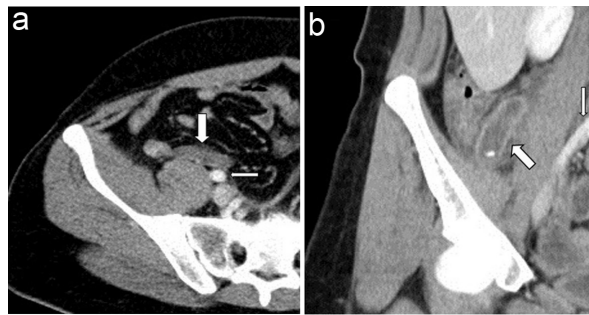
Example of the severity of mural enhancement. On contrast-enhanced abdominal CT scans, if the severity of mural enhancement (thick arrow) was less pronounced (a) than the right external iliac artery (fine arrow), it was graded as 1. If the severity of mural enhancement (thick arrow) was equal or more pronounced (b) than the right external iliac artery (fine arrow), it was graded as 2. CT, computed tomography.
